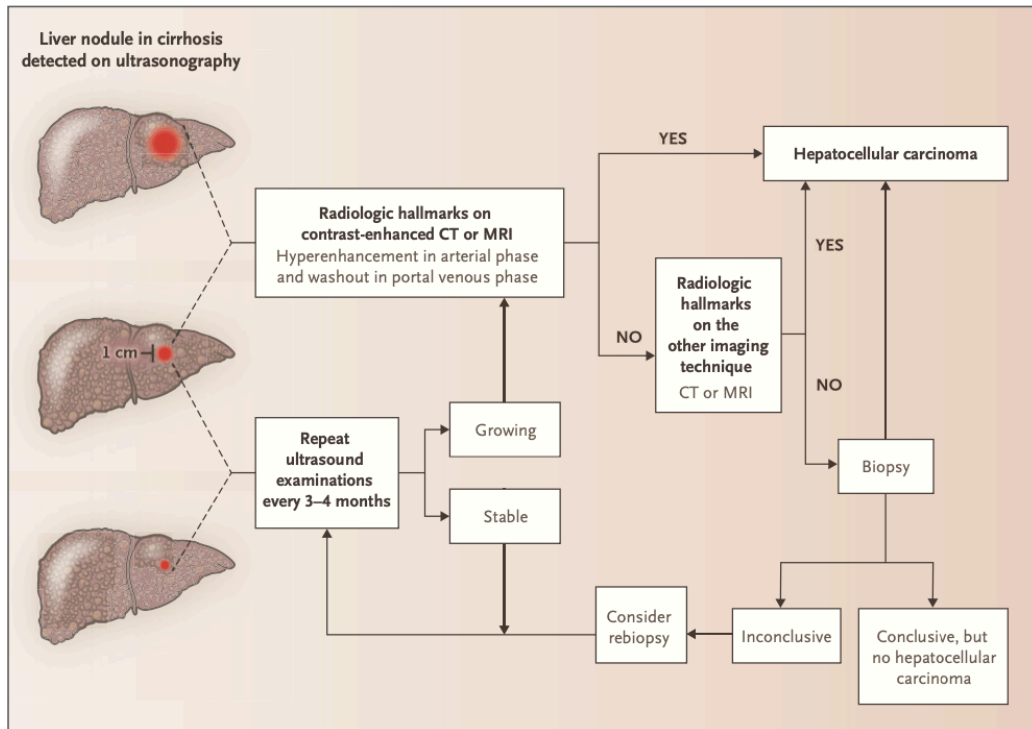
Diagnosis Algorithm for a Liver Nodule in Patients with Cirrhosis. CT: Computed Tomography, MRI: Magnetic Resonance Imaging. From Villanueva A et al. *N Engl J Med.* 2019 (3).
